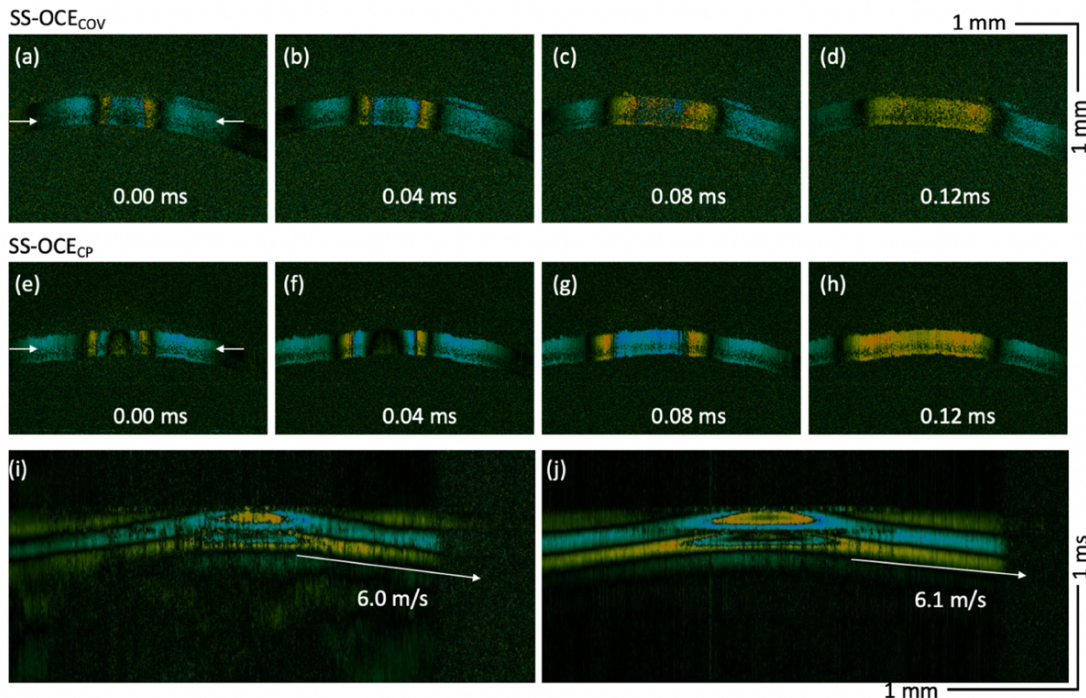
Elastic wave in rabbit cornea. (a)-(d) Time-lapse Doppler OCT B-scans from SS-OCE<sub>COV</sub> system. (e)-(h) Time-lapse Doppler OCT B-scans from Common-path OCE system. (i) and (j) Spatiotemporal Doppler OCT at a depth indicated by white arrows in (a) and (e), respectively.
